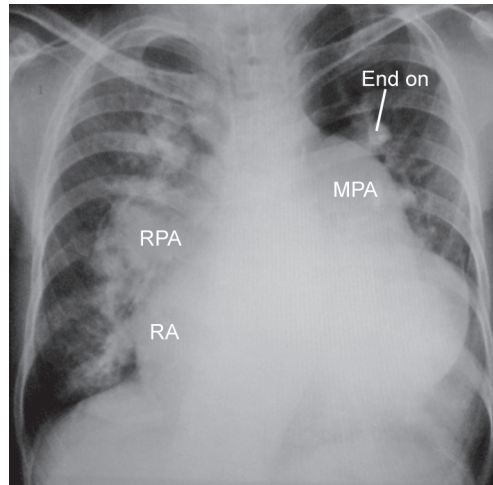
Chest X-ray in atrial septal defects with severe pulmonary hypertension.
